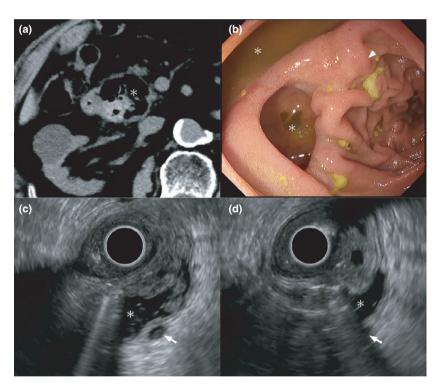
(a) Computed tomography image of a patient who underwent pancreatobiliary endoscopic ultrasound (EUS) reveals a large periampullary diverticulum (asterisk). (b) Endoscopic image of the periampullary diverticula and the papilla (arrowhead). (c, d) EUS image shows that air trapped in periampullary diverticula disturb acoustic coupling, and delineating the biliary duct and pancreatic duct (arrow) was difficult.
